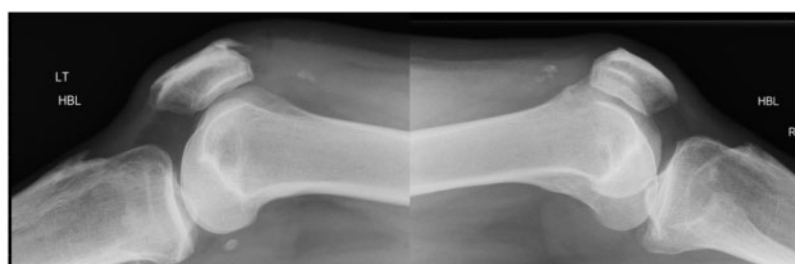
Radiographs from subsequent presentation.
